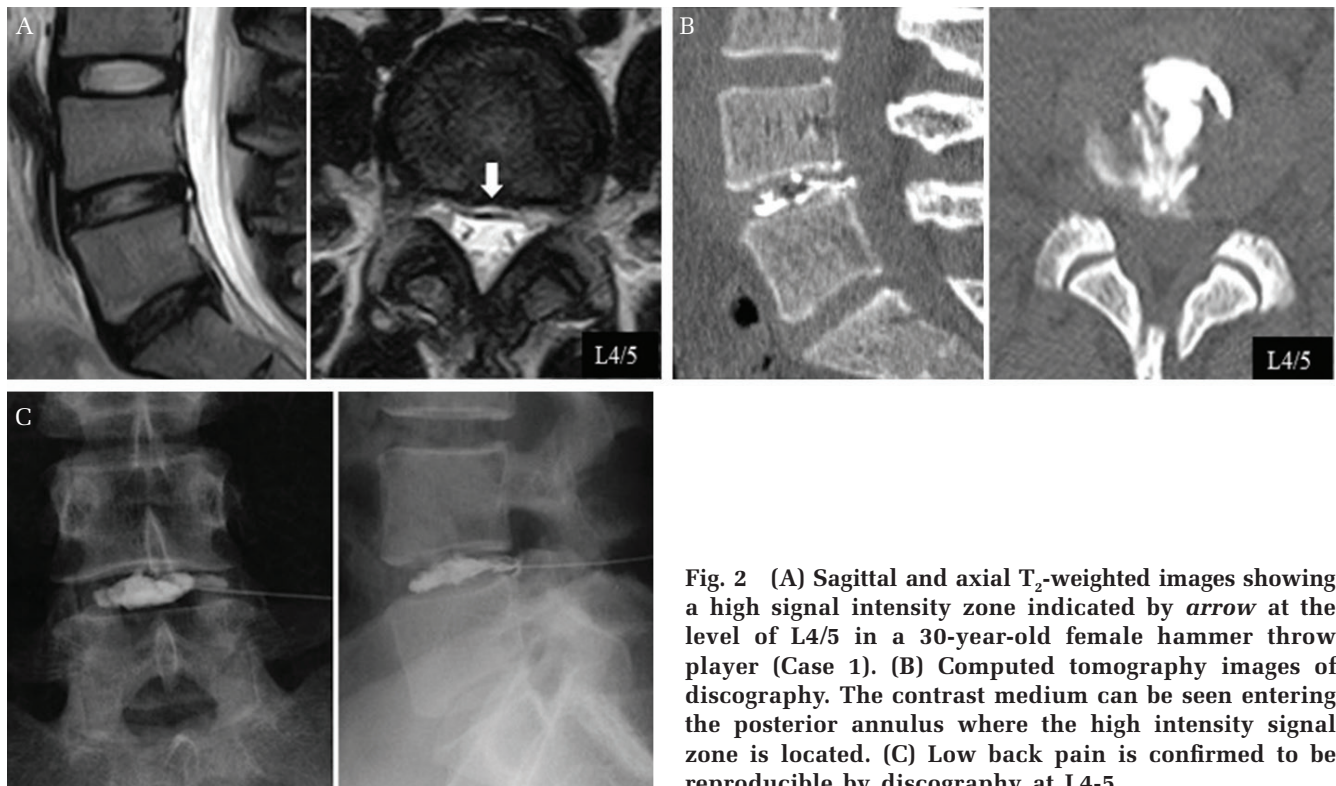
(A) Sagittal and axial T<sub>2</sub>-weighted images showing a high signal intensity zone indicated by *arrow* at the level of L4/5 in a 30-year-old female hammer throw player (Case 1). (B) Computed tomography images of discography. The contrast medium can be seen entering the posterior annulus where the high intensity signal zone is located. (C) Low back pain is confirmed to be reproducible by discography at L4-5.
